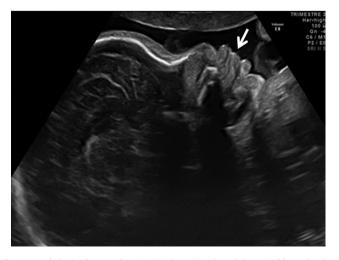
Morphologic ultrasounds at 32 GW (gestational weeks): sagittal lane showing macroglossia (white arrow).
